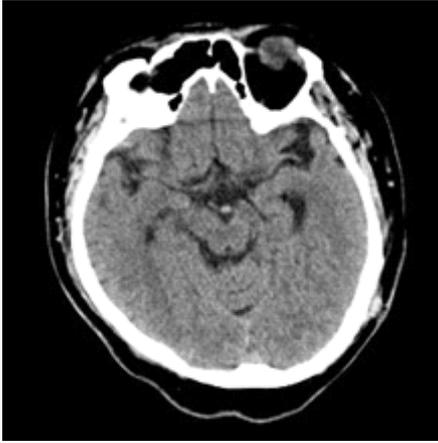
Brain CT was performed on the day before surgery when the consciousness was semi-coma. As a results of reading, no specific finding was observed other than mild brain atrophy.
